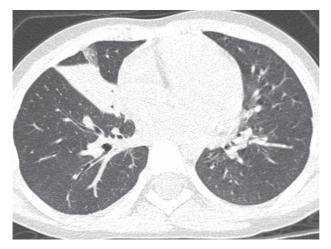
Female at the age of 4 years and 1 month with common variable immunodeficiency. Female patient at the age of diagnosis. At the age of 4 years, children are usually too young to perform pulmonary function test maneuvers. The chest radiograph demonstrates some aspecific increased linear markings in the right paracardiac area. High-resolution computed tomography scan demonstrates partial atelectasis of the middle lobe and cylindrical bronchiectasis in the right lower lobe.
